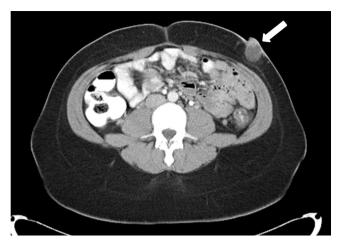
CT scan of abdomen with contrast (axial view) showing an abdominal wall mass  $3.2\,\mathrm{cm}$  x  $2.4\,\mathrm{cm}$  x  $2.3\,\mathrm{cm}$  (white arrow).
